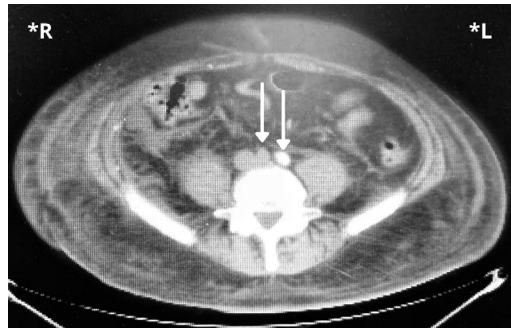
Contrast abdominal CT showing full occlusion of right common iliac artery (right side arrow) and the presence of a minor plaque within the left common iliac artery (left side arrow). R: right, L: left.
